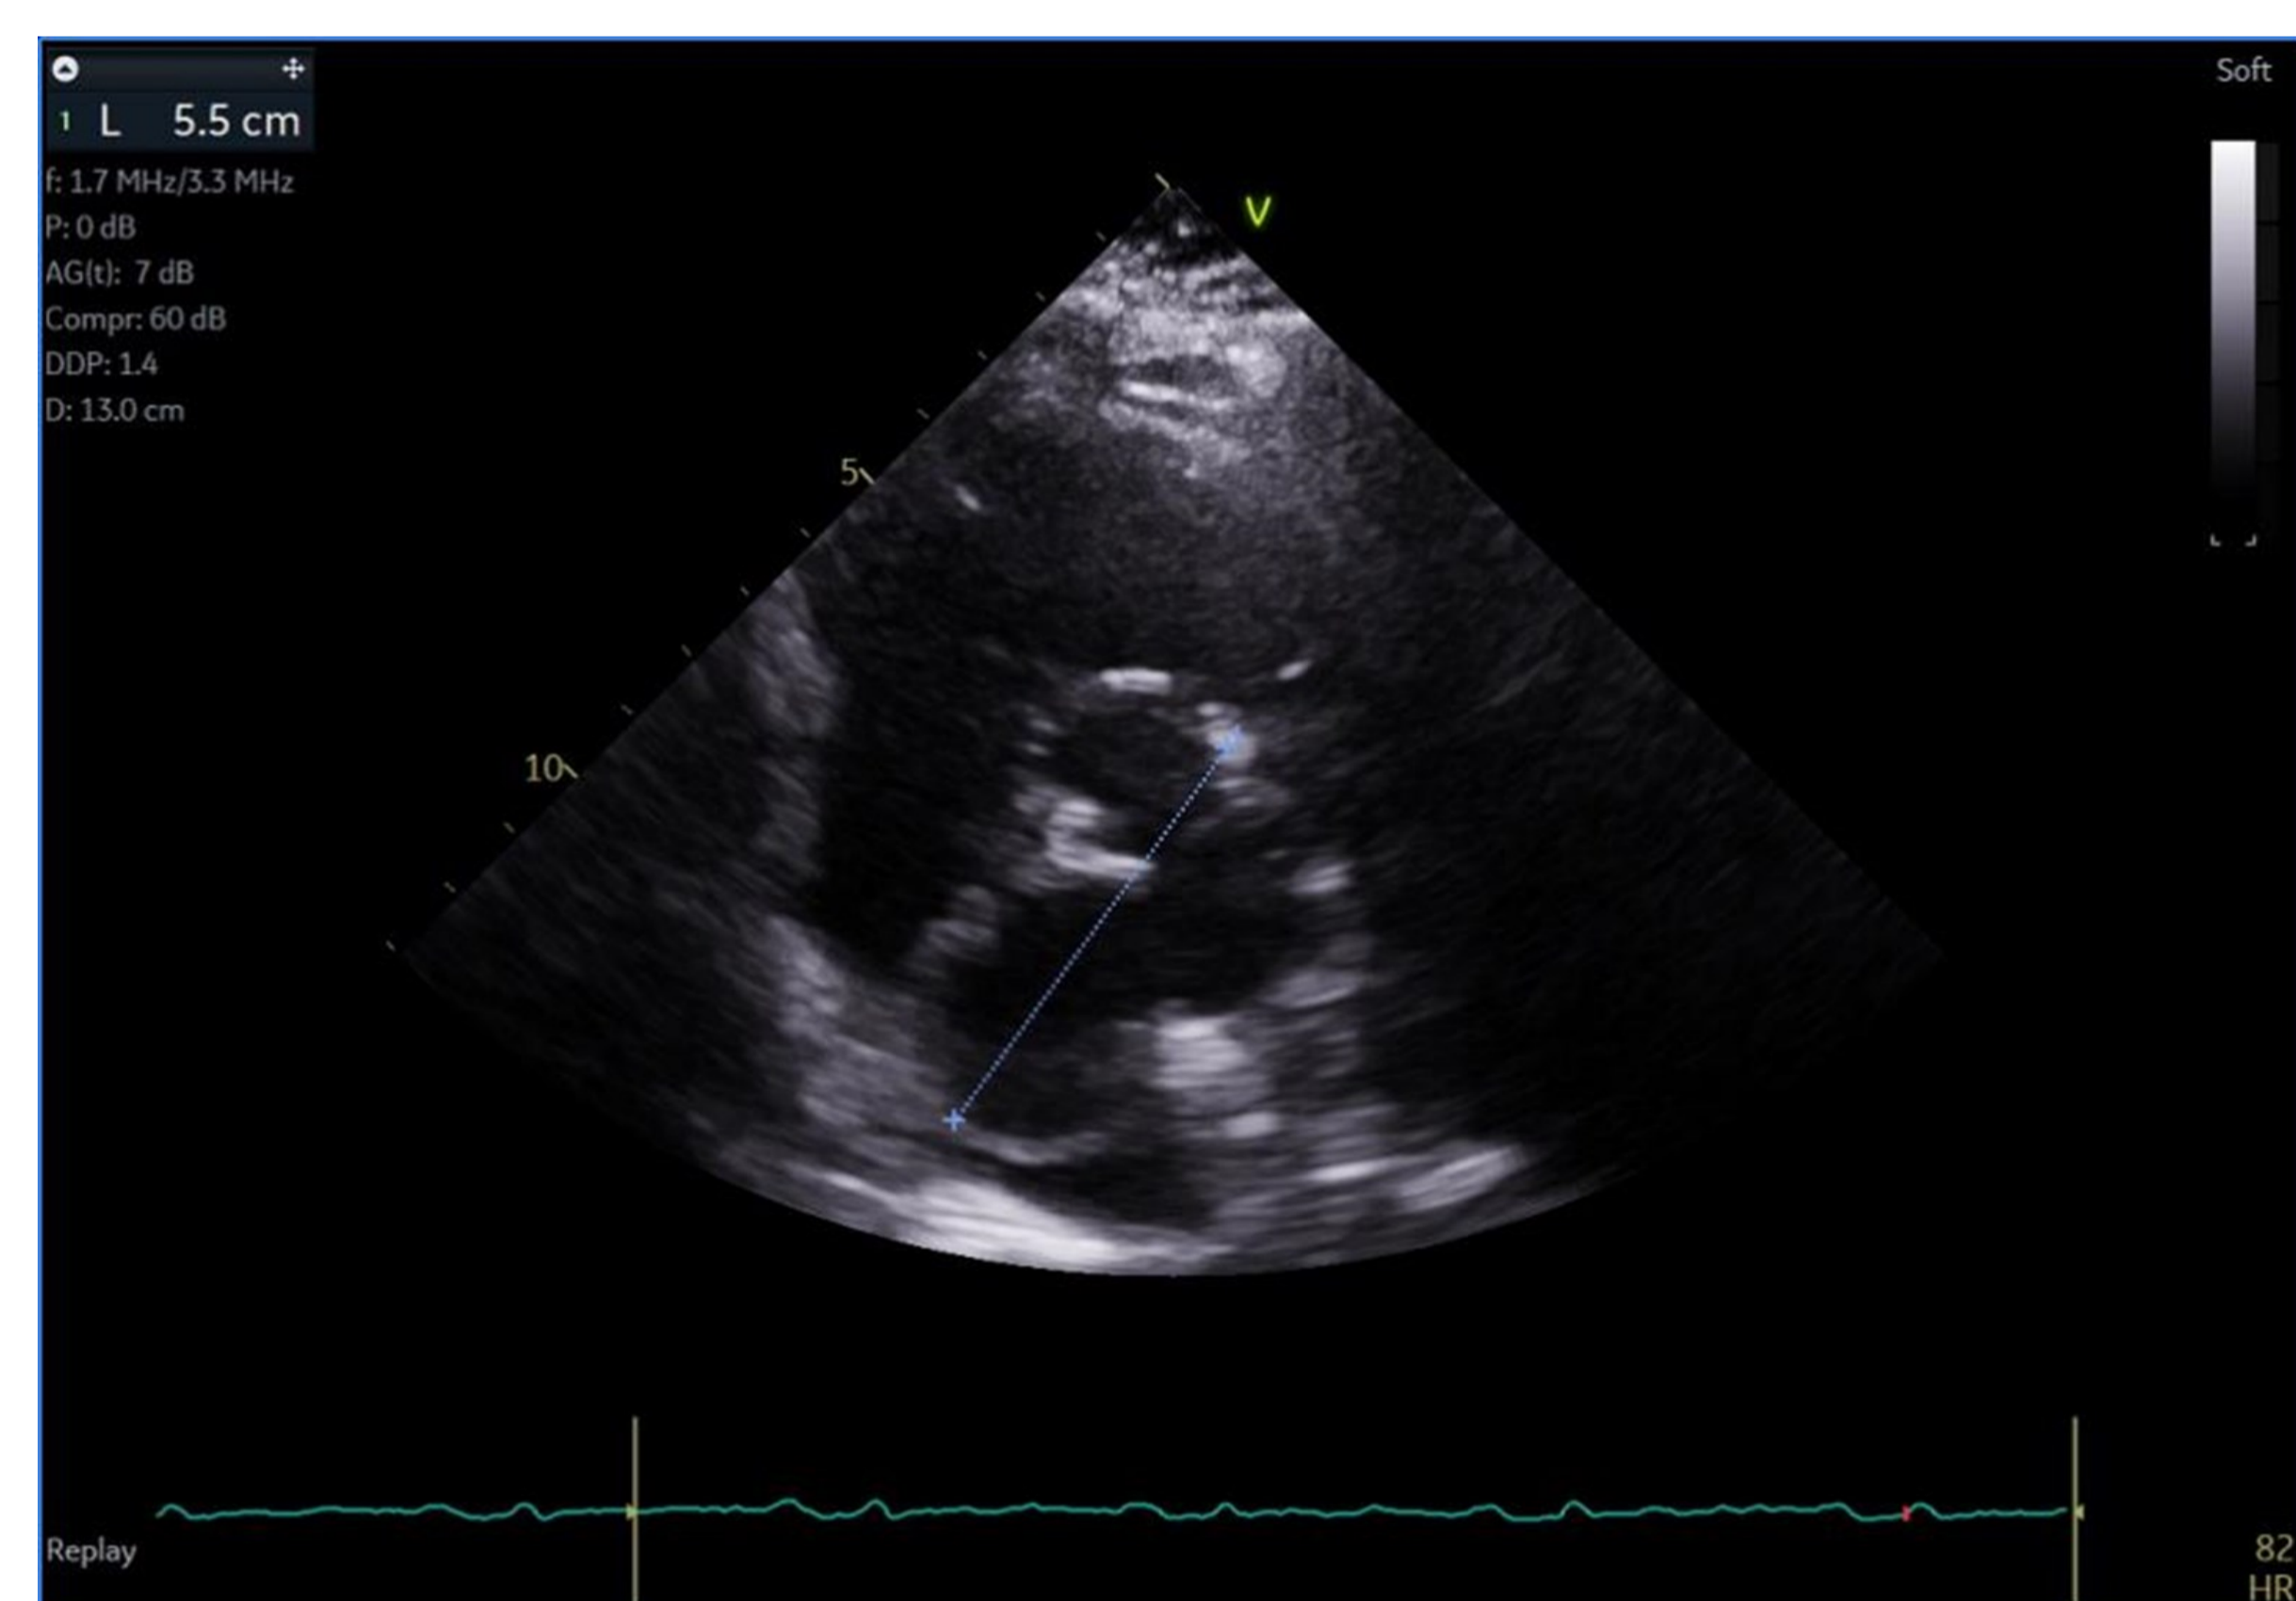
Parasternal Long Axis Showing the aortic root dimension of 5.8cm
